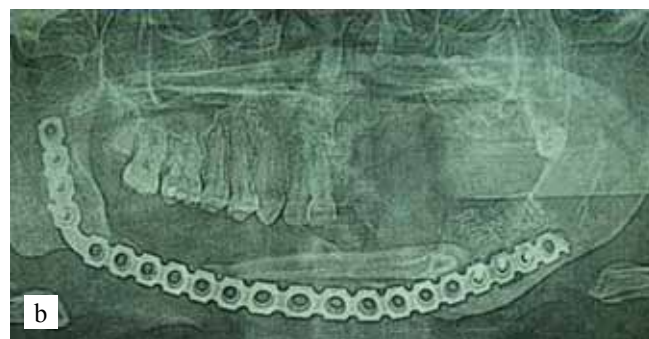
a – appearance of the patient when applying to the clinic of maxillofacial surgery of the Sechenov First MSMU; b – orthopantomogram, condition after resection of the mandible and fixation the reconstructive plate of mass production
